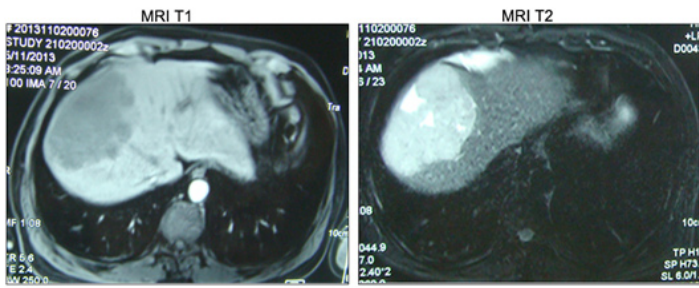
Abdominal MRI of the patient showing a hypoattenuating lesion.
